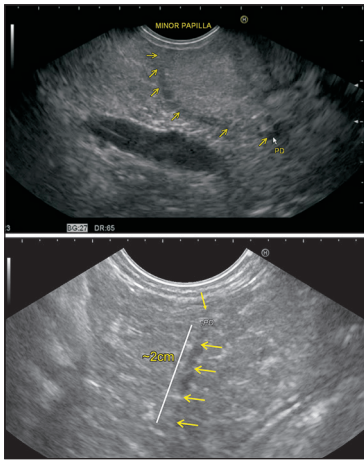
Application of color Doppler can identify the anechoic duct coming to duodenal wall within the dorsal hyperechoic part of the pancreas. During withdrawal the opening of the minor papilla is about 1.5-2 cm. above the major papilla. The length of the duct of Santorini that can be visualized is variable and depends on the amount of pancreatic tissue that it drains. Normally the minor papillary duct is seen only for a distance of about 1-2 cm. In the first case the course of the duct is seen for a longer distance of more than 3 cm whereas the second case the PD is seen only for a distance of about 2 cm. PD: Pancreatic duct
